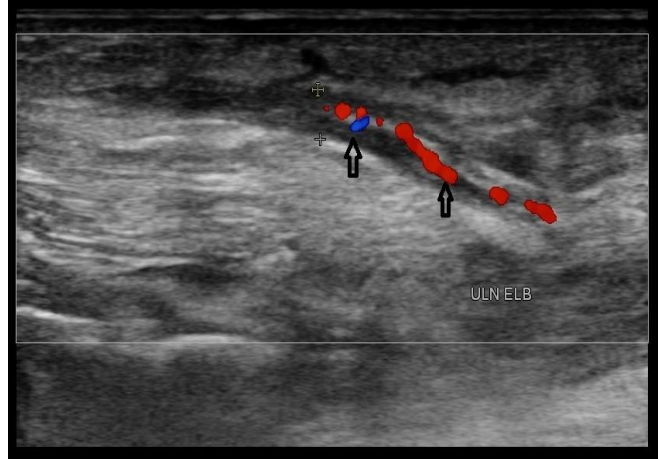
(b): Colour Doppler of ulnar nerve behind medial epicondyle in leprosy showing increased intraneural vascularity (arrow head).
